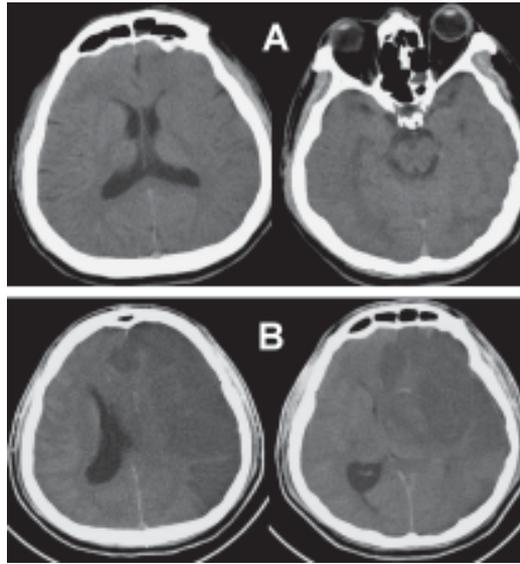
The patient's brain computed tomography on presentation (A) and 37 hours after admission (B).
